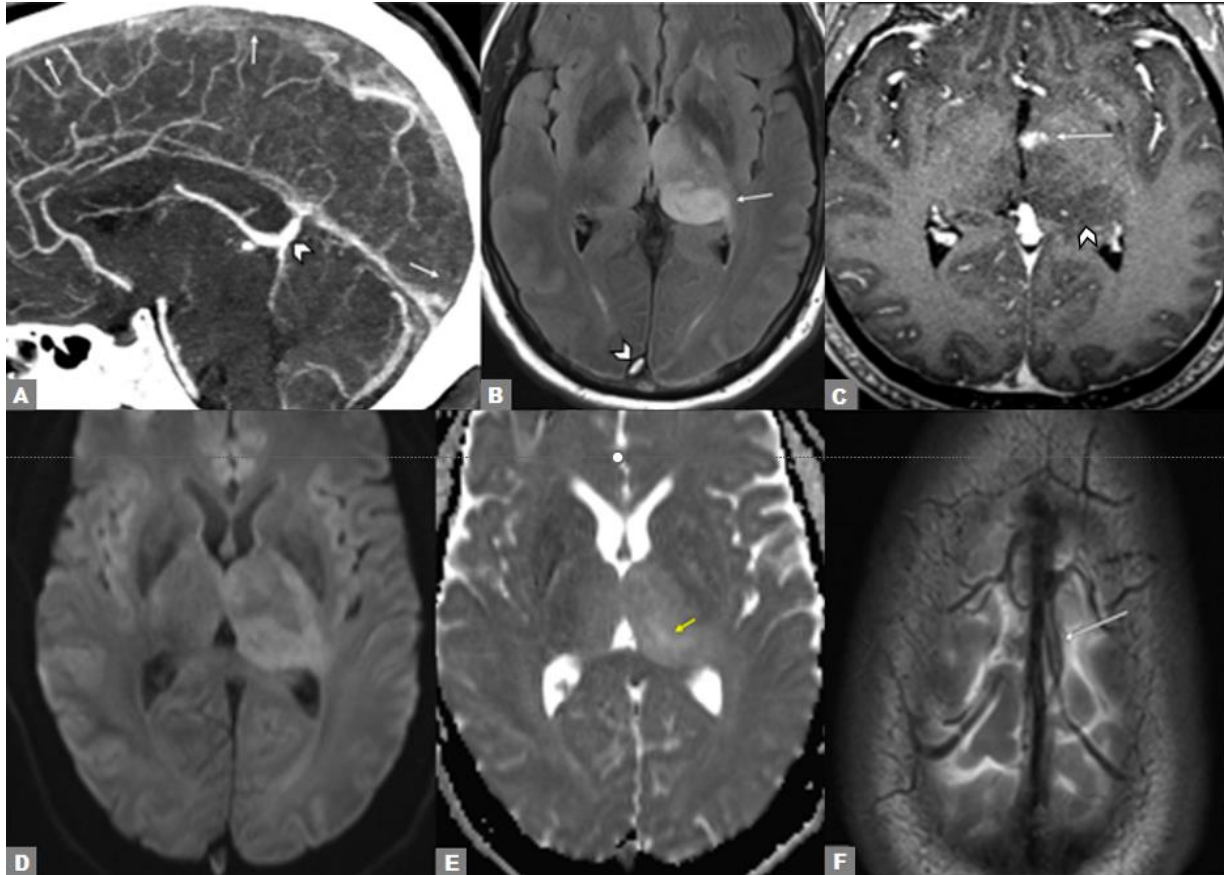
CT Venogram and MRI of the Brain. (A) Initial CT venogram demonstrates filling defects in the superior sagittal sinus (SSS, arrows). Deep cerebral veins (arrowhead) enhanced normally. (B) Axial T2 FLAIR image demonstrates expansile left thalamic T2 hyperintensity (arrow) and SSS thrombosis (arrowhead). (C) Subsequent postcontrast T1 image shows focal enhancement (arrow) within the thalamic lesion (arrowhead). (D) DWI and (E) ADC demonstrate facilitated diffusion (yellow arrow) which did not help distinguish between venous congestion and glioma. (F) Axial T2 image demonstrates left vein of Trolard thrombosis (arrow).
